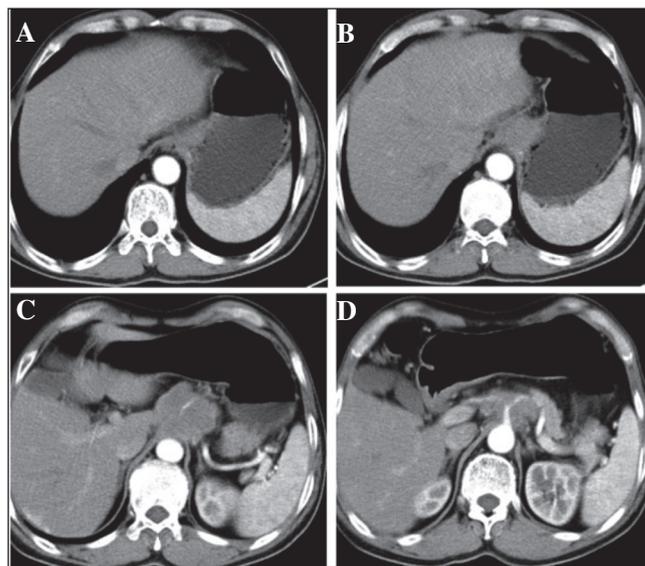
Computed tomography revealing a heterogeneously enhanced lesion between the abdominal aorta and the stomach.
